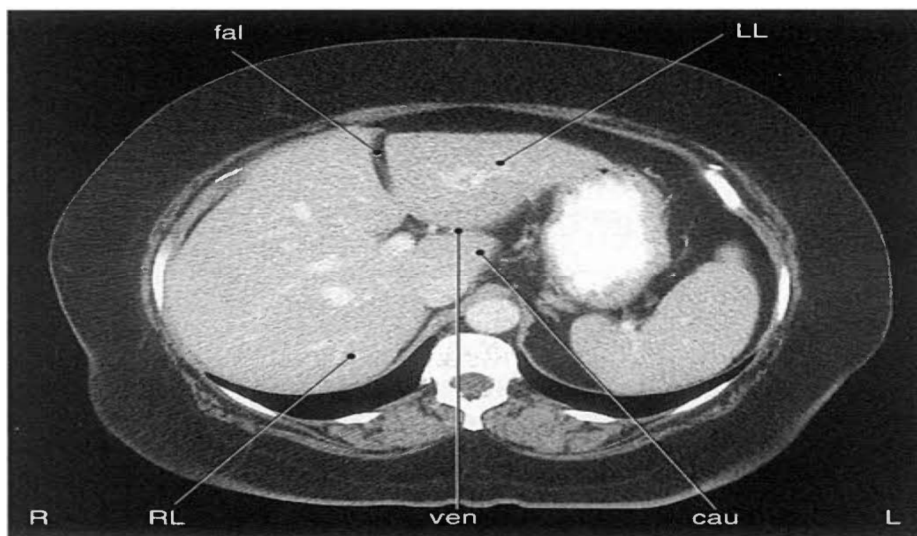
Axial CT scan of abdomen with lobes of liver(Lorrie, 2007).
